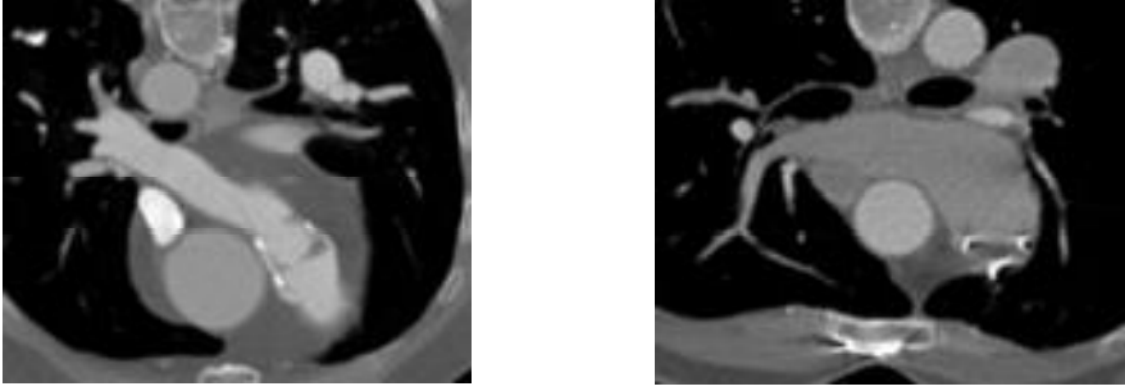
CT of Patient 1 (*left*) and Patient 2 (*right*) provided by Niguarda Hospital.
